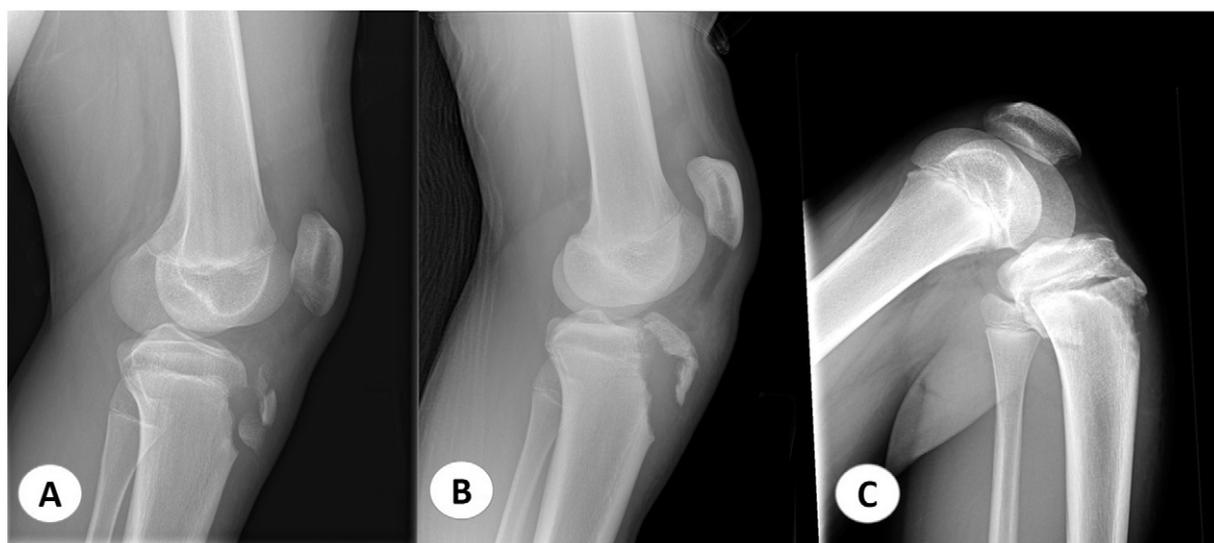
Plain radiographs of the knee show different types of tibial tubercle fracture according to Ogden classification. A) Patient with type IIB fracture; B) patient with type IIIB fracture; C) patient with type IV fracture.
